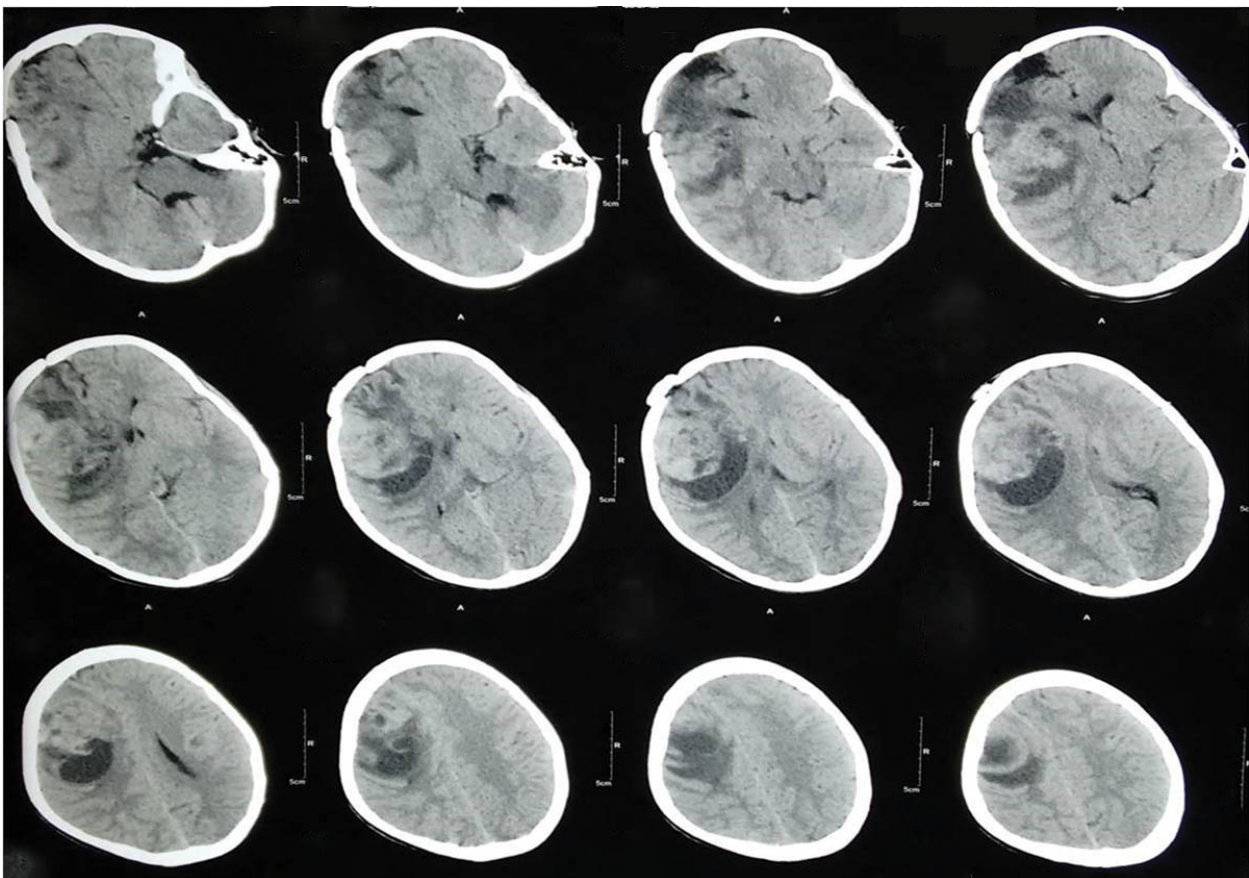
Plain CT scan showing recurrence of tumor.
